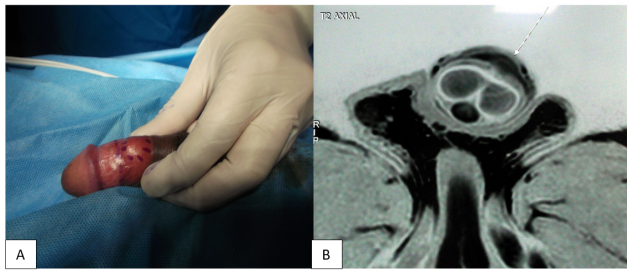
A): Nodule on the dorsum of the penis marked by methylene blue; B): MRI T2 phase axial section showing the nodule
